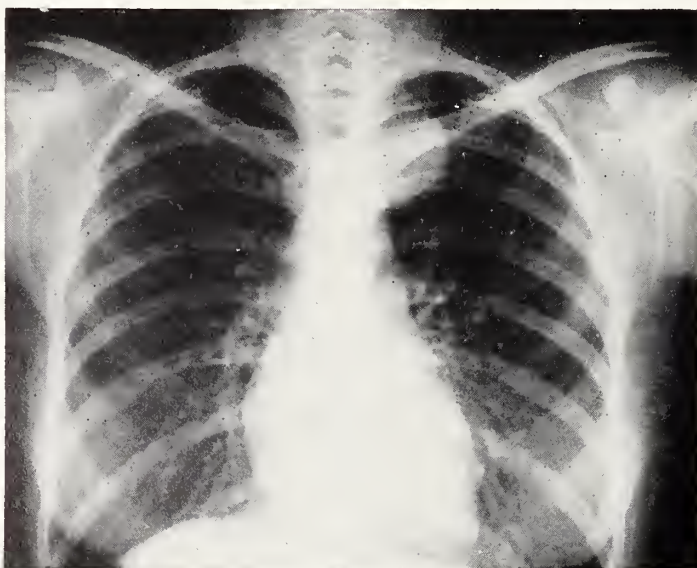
Chest X-ray demonstrates mass in the left side of the mediastinum.
